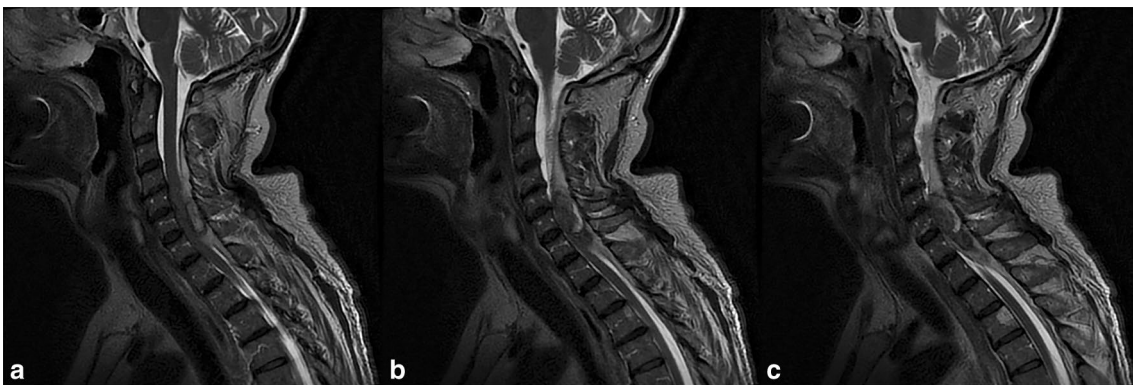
Pre-operative sagittal T2 weighted spinal MRI reveals the same lesion with heterogeneous aspect
